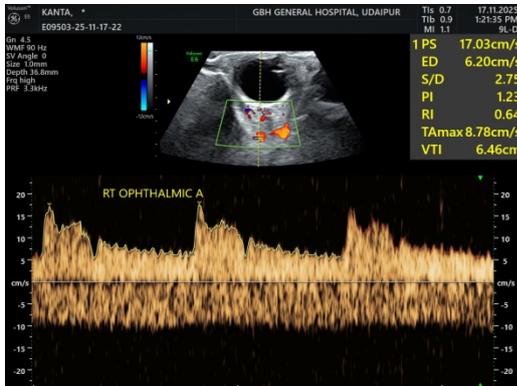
Spectral Doppler waveform of the right ophthalmic artery showing low-resistance flow with preserved diastolic velocity. Measured parameters include PSV 17.03 cm/s, EDV 6.20 cm/s, PI 1.23, and RI 0.64.
